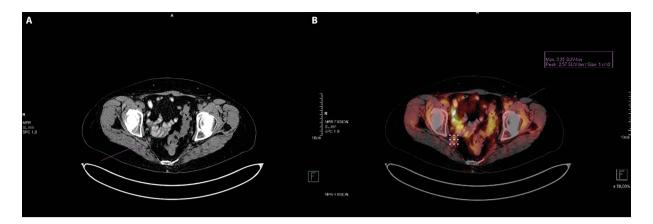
Hypermetabolic lesion suspected of recurrence located in mesorectal adipose tissue; A. Computed tomography (CT) presentation; B. Positron emission tomography (PET/CT) presentation
